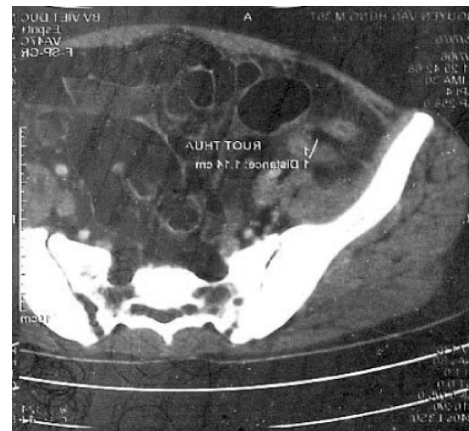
Abdominal CT scan showed ascites and bowel wall thickening
